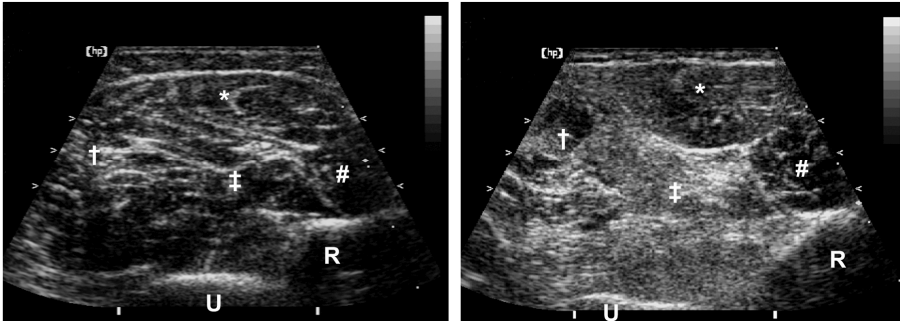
Transverse ultrasound image from the forearm flexors of a 56-year-old healthy woman (left-hand panel) and a same aged female patient with recessive myotonia congenita (right-hand panel). Comparison of the two images reveals a typical pattern within the forearm flexors of the patient, with predominantly higher echo intensities for the flexor carpi ulnaris (†) and flexor digitorum profundus (‡), and relatively spared flexor digitorum superficialis (\*) and flexor carpi radialis (#). U: ulna; R: radius.
